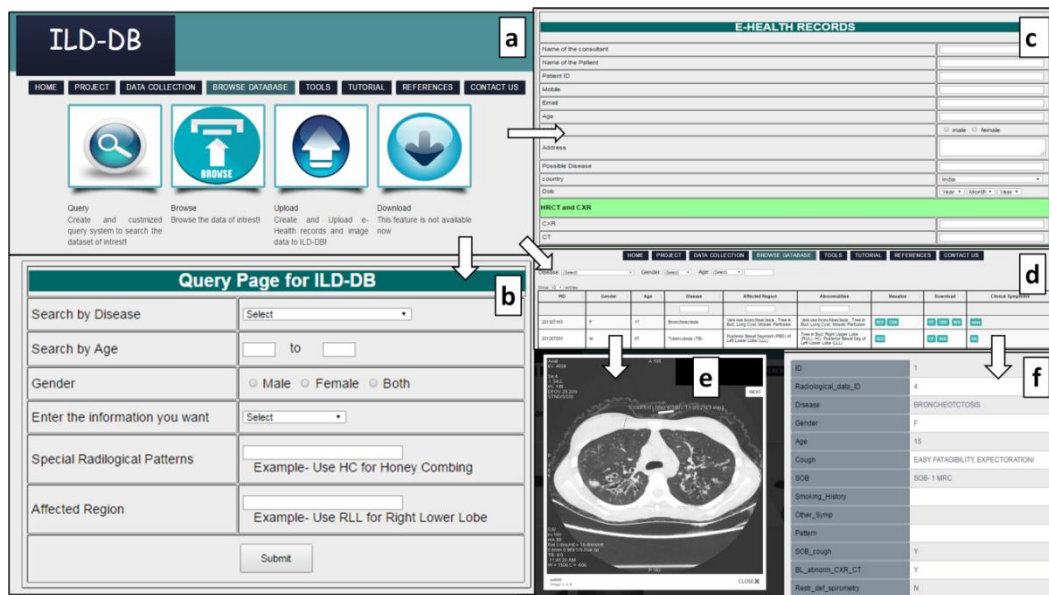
Overview of ILD-DB resource. (a) Access of information from ILD-DB using ‘Search’, ‘Query’, ‘Upload’ and ‘Download’ options; (b) Accessing different categories of data using ‘Query’ options, data associated with disease by choosing ‘Disease’, ‘Radiological Patterns’ and/or “Affected Region”; (c) ILD individual patient data submission through “Upload” option for new cases using EHR form; (d) Patients data in the tabular format with hyperlinks to access more specific data for a single patient.; (e) Visualization window for marked radiological patterns of HRCT; and (f) Clinical information of ILDs patient.
